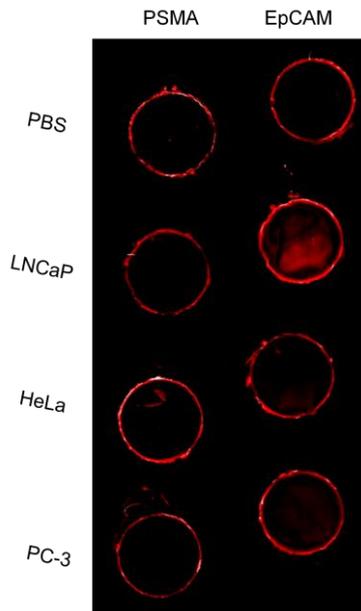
Glass slide for PSMA and EpCAM detection by Cy5 read at 635 nm
